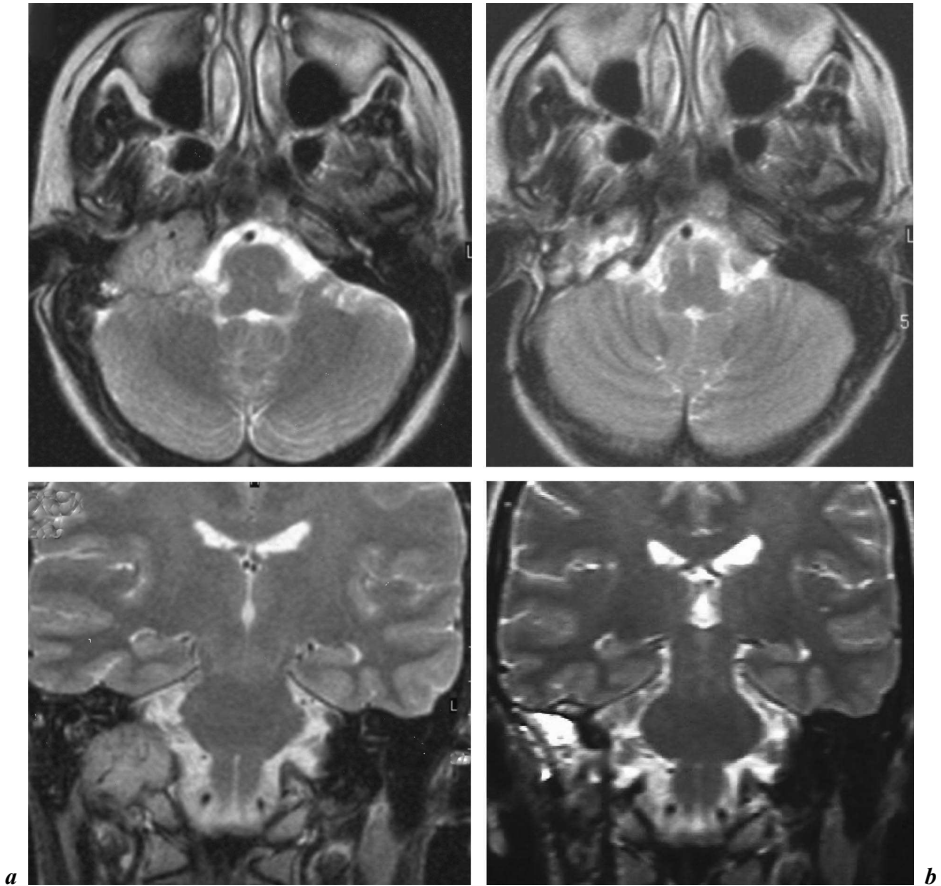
a* Pre-radiosurgical MRI (axial and coronal views) in sequence T2 flair with gadolinium in patient 10 presenting a right-sided glomus jugulare tumor after embolization and surgical resection. Patient, 36-year-old female, had a permanent percutaneous gastrostomy three months before embolization. Radiosurgery was realized on September 2002 and 12 Gy were applied to the tumor margins at the 80% isodose volume curve. In follow-up 1 month after SRS patient presented a clinically significant rehabilitation from cranial nerve X and removed definitively the gastrostomy. *b* Latest MR scan (axial and coronal views with the same sequence) performed 37 months after SRS revealing the maintenance of considerable reduction tumor volume.
